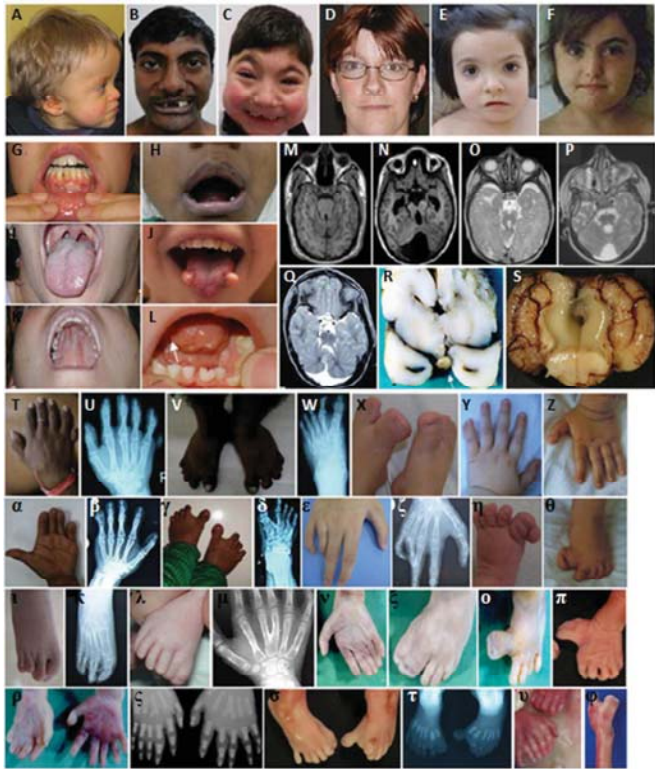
Clinical pictures, X-rays and brain MRI of OFD cases. Case 3a (M), case 3b (N), case 4 (C, P, X), case 5 (μ), case 6a (B, T, U, V, W), case 6b (H, α , β , γ , δ), case 7 (G), case 8 (E, L, Q, ϵ , ζ , ι , κ), case 10 (J, Y), case 11 (O), case 17 (D, I, K), case 19 (G), case 22 (A, η), case 25 (ν , ξ), case 26b (F, Z, θ), case 27 (R, \omicron , ρ , ς) case 28b (S, σ , τ), case 29 (υ , ϕ) with facial dysmorphism (A-F) including low-set ears (A), median pseudo-cleft of upper lip (H), missing incisors (B) or severe microcephaly (C), abnormal frenulae (G), cleft palate (K), lobulated tongue or hamartoma (I, J, L), pre and postaxial polydactyly of hands and feet (T, U, X, Y, η , θ , λ , μ - ϕ), broad duplicated and/or deviated hallux (V, W, X, η , θ , ι , κ , ξ , \omicron , π , ϕ), Y-shaped metacarpal abnormality (μ , ς), hypothalamic hamartoma (R), cerebellar hypoplasia (S), brain MRI with MTS (M-Q).
